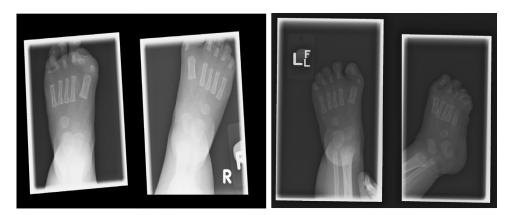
Plain radiograph of patient's left and right foot showing hallux valgus.
